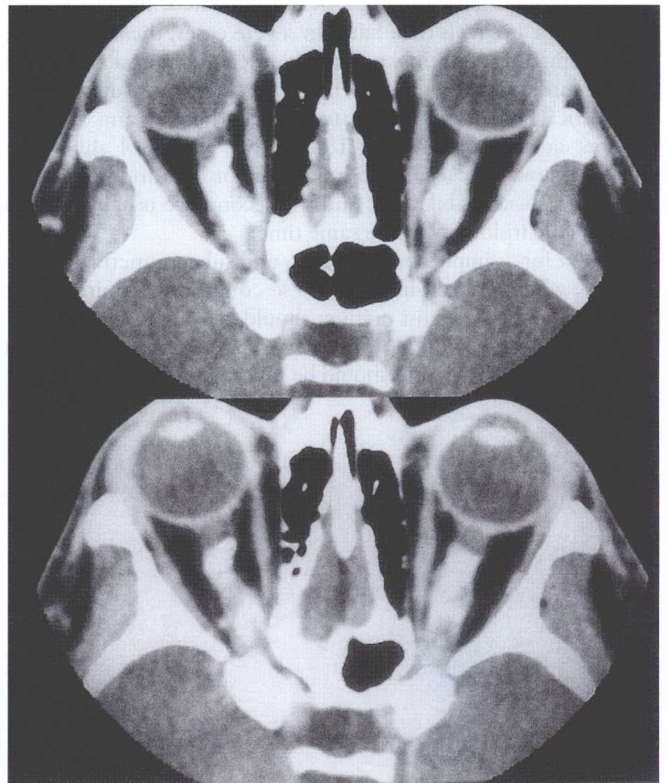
High-resolution CT through orbits, showing dense calcification of optic nerve sheaths typical of optic nerve meningioma (courtesy of Dr Juliette Britton).
